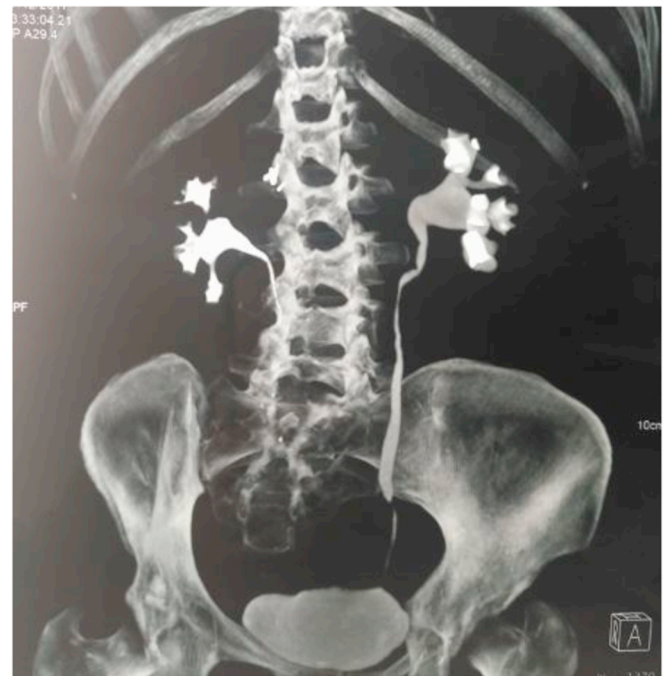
Postoperative abdominal computed tomography shows the absence of local recurrence and postoperative complication except for slight dilation of the excretory cavities.
